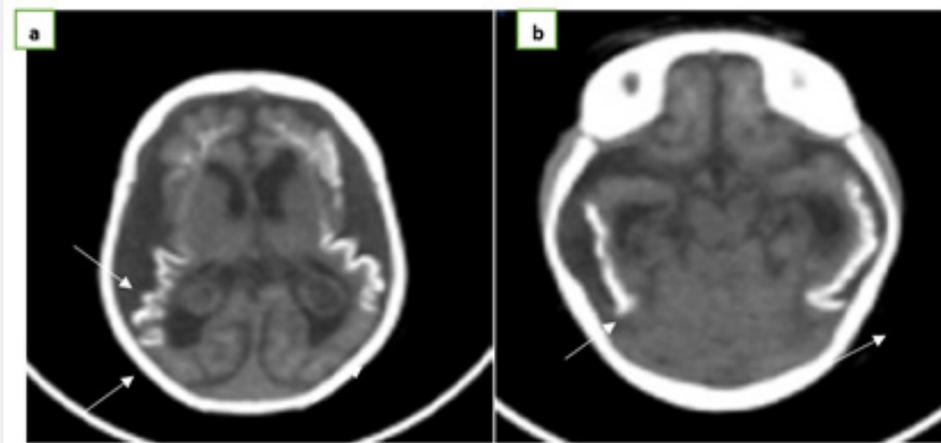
Brain CT scan without CDP injection shows subcortical calcifications off onto-temporo-parieto-occipital gyri form appearance, bilateral bilat, bilateral enlargement of subarachnoid pericerebral spaces, increased size of lateral ventricles and bilateral hypertrophy of the choroid plexus as part of Sturge Weber Syndrome.
